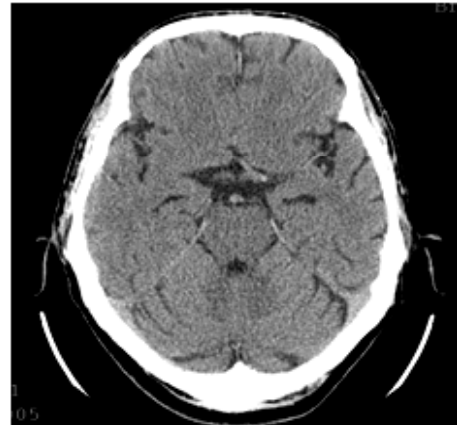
Same patient T., 61 years old (TDR-2) before transcatheter intracerebral laser exposure. Brain CT.
